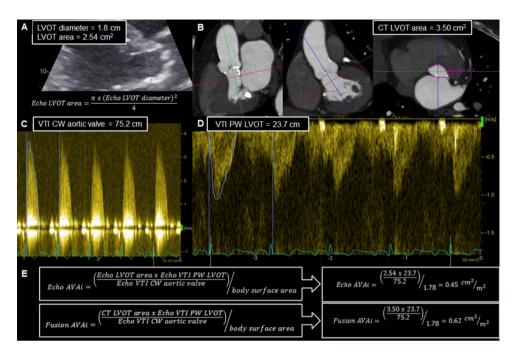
Evaluation of the aortic valve area index (AVAi) by two-dimensional Doppler echocardiography (Echo) and by fusion of multi-detector row computed tomography (CT)-derived and echocardiographic measurements. Using echocardiography, the left ventricular outflow tract (LVOT) diameter was measured 5 mm below the aortic annulus in the parasternal long-axis view and the LVOT area was calculated (*panel A*). Using CT, the LVOT area was located 5 mm below the aortic annulus and planimetered in the reconstructed double oblique transverse view in systole (*panel B*). Continuous-wave (CW) Doppler on the apical 5-chamber view was performed to measure the velocity time integral (VTI) of the aortic valve (*panel C*). Pulsed-wave (PW) Doppler recordings of the LVOT were obtained by placing the sample volume 5 mm below the aortic annulus and the VTI of the flow at the LVOT was measured (*panel D*). By utilizing the continuity equation, the Echo AVAi and fusion AVAi were calculated incorporating the echocardiographically estimated LVOT area and CT-derived LVOT area, respectively. In both calculations, the VTI of the LVOT and the aortic valve area were used (*panel E*). In this example, reclassification to moderate AS was possible by calculating the fusion AVAi.
